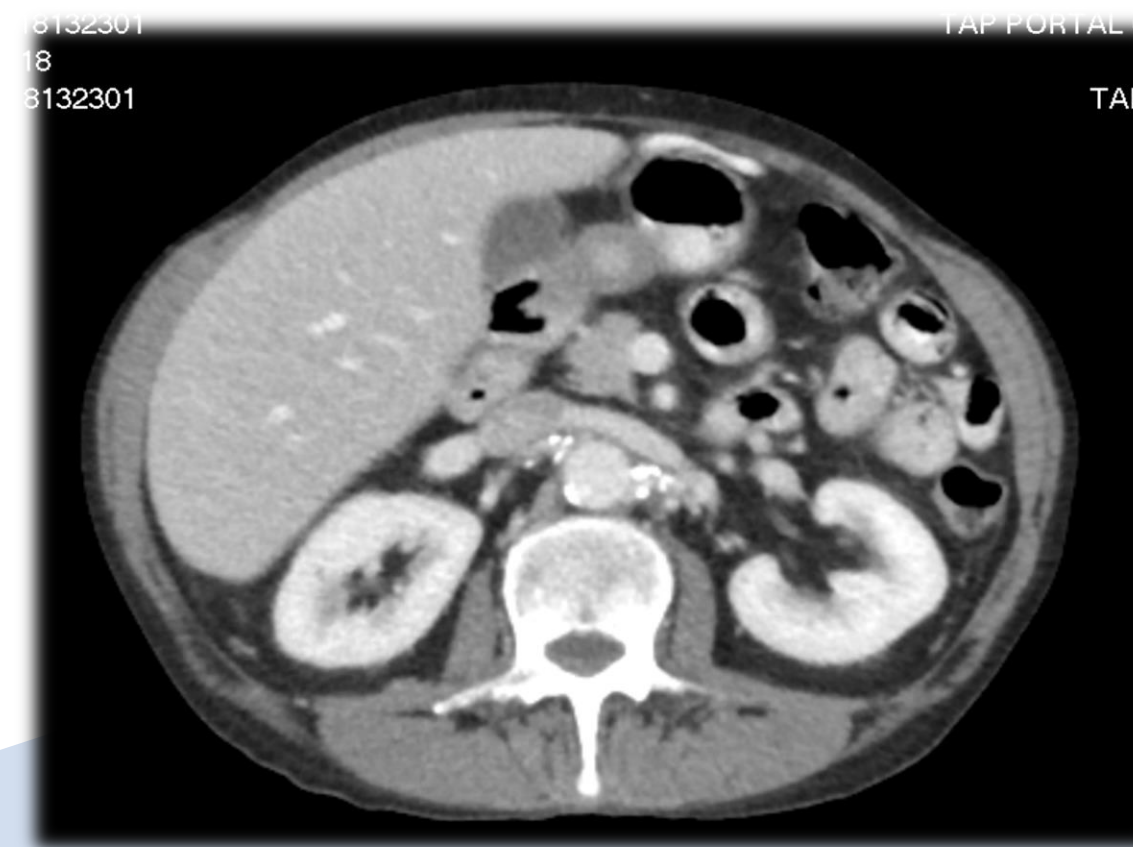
Thoraco-abdomino-pelvic CT
